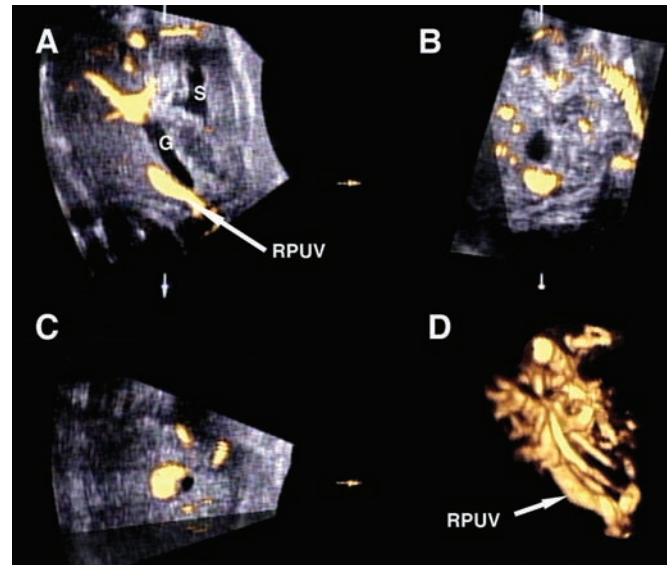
Multiplanar display and a rendered display of a fetus at 25 weeks' gestation with persistent right umbilical vein. (A) Transverse plane through the fetal abdomen at the level obtained to measure the abdominal circumference: S, stomach; G, gallbladder; RPUV, right persistent umbilical vein. The right umbilical vein passes lateral and to the right side of the gallbladder connecting the left portal vein. This is the intrahepatic form of the right umbilical vein. (B) A perpendicular view to plane A. (C) A coronal view to plane A. (D) The rendered 3D power Doppler view with the arrow pointing at the persistent right umbilical vein. Note that all these four windows are interactive with each other. Windows A and D can be correlated to identify the right umbilical vein both in cross-sectional and in rendered view.
